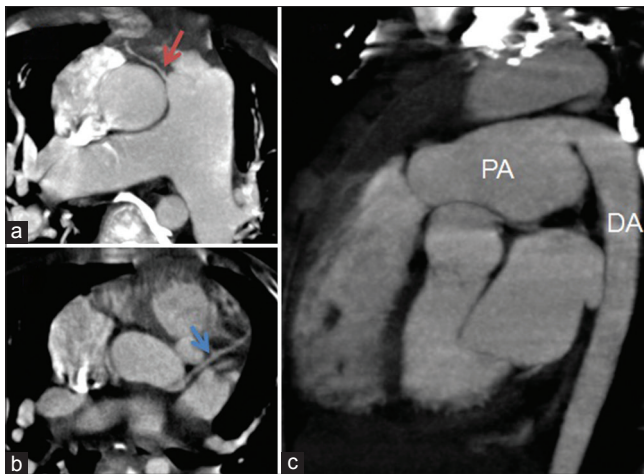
(a and b) The axial section of computed tomographic angiogram (maximum intensity projection) images showing anomalous origin of right coronary artery from pulmonary artery (red arrow) and normal left coronary artery origin (blue arrow). (c) Sagittal section of computed tomographic angiogram (maximum intensity projection) image showing dilated PA connected to DA. PA: Pulmonary artery, DA: Descending aorta
